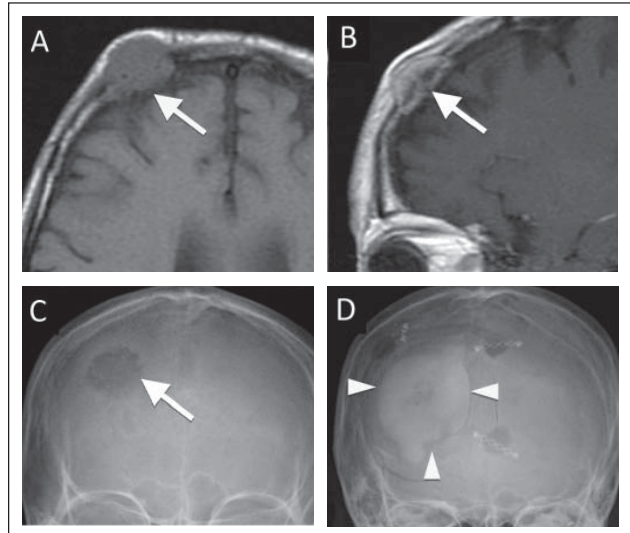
A 70-year-old woman with calvarial metastasis from lung cancer presenting with cosmetic problem in the forehead. (a) Pre-enhanced axial and (b) post-enhanced sagittal MR images demonstrating a mass lesion with focal invasion into the skin and dura mater. (c) Skull X-rays showing an osteolytic lesion (white arrow), and (d) surgical results of resection with a wide margin and reconstruction in the frontal bone (arrow heads).
